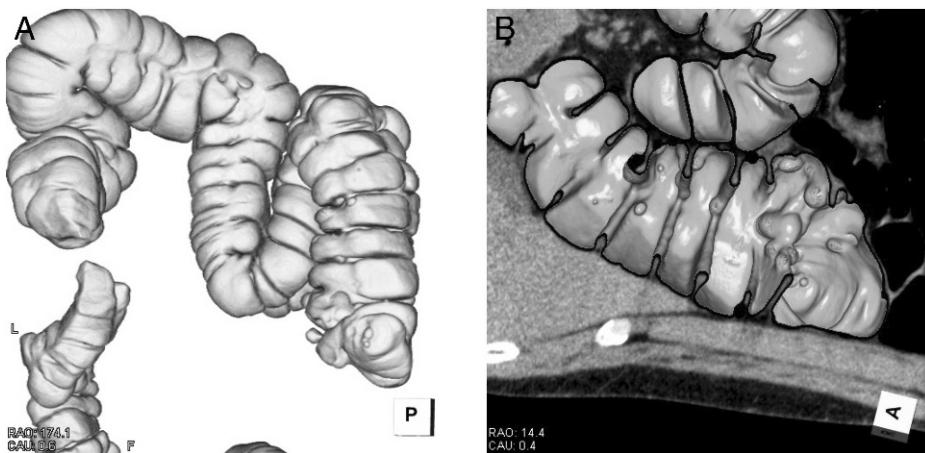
CT colonography. (A) Multiple pneumatic lesions from the ascending colon to the transverse colon are observed. (B) Multiple pneumatic lesions in the ascending colon are observed.
